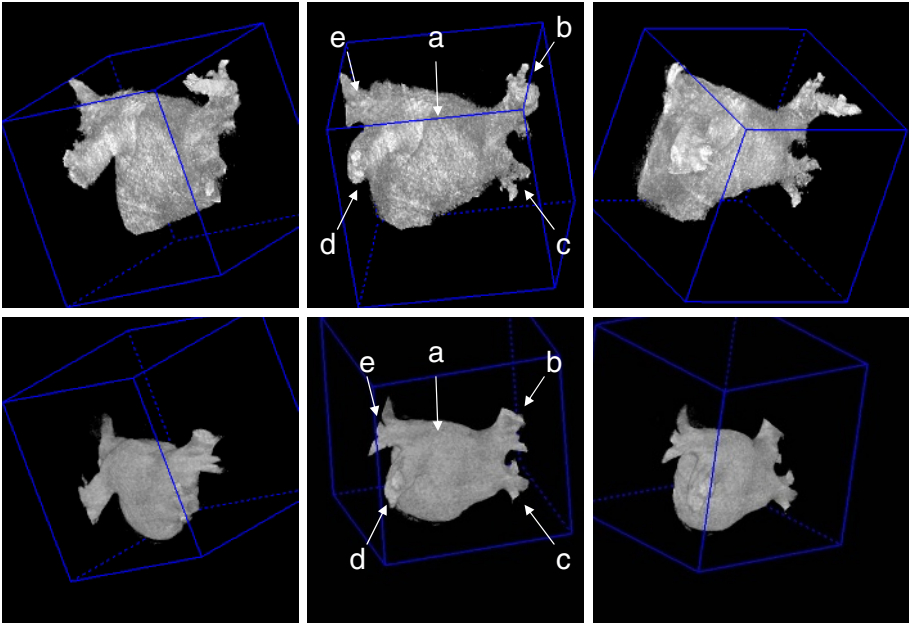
Top row shows volume renderings from the reconstructed 3DRA run. (a) indicates the LA structure, (b) shows the right superior PV, (c) depicts the right inferior PV, (d) shows the left inferior PV and (e) indicates the left superior PV. Lower row displays renderings from the corresponding pre-operative CT data.
